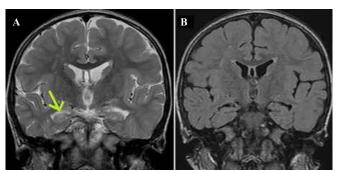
Right hippocampal signal abnormality and volume loss in a 9-yearold boy. Increased signal with a volume loss in the right hippocampus at coronal T2-weighted fast spin-echo MR (A) and a volume loss at coronal fast fluid-attenuated inversion recovery (FLAIR) (arrow) MR images (B). MR = magnetic resonance.
